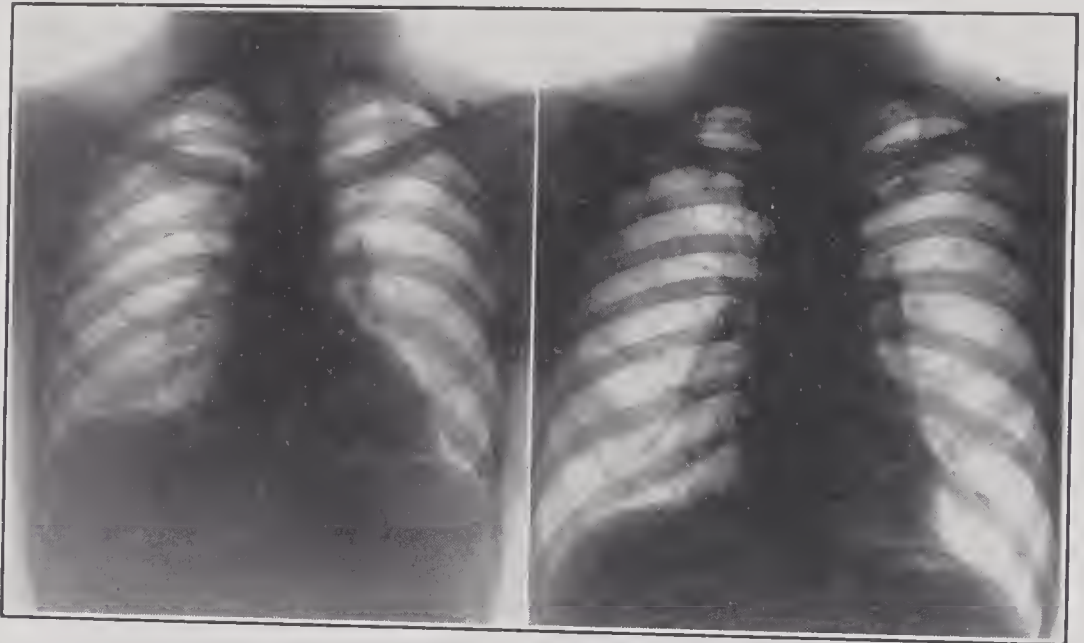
X-ray photographs of a normal chest taken at the end of expiration (left) and at the end of inspiration (right). Note the raised ribs, lowered diaphragm, greater air space, and more pendant heart after breathing in. (The lungs themselves do not show except as occasional calcified lymph glands and bits of bronchi throw a lacy shadow in the otherwise clear air space.) (Courtesy Roentgenology Staff, Billings Hospital.)
